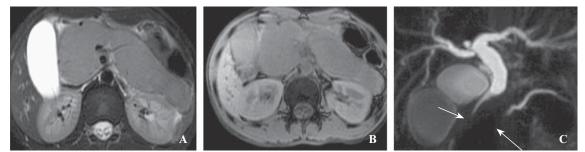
Plain MRI with abdominal axial T_2 (A) and T_1 (B) weighted images showing diffuse enlargement of the pancreas and homogeneous long T1 and long T_2 weighted signal intensities; C: Magnetic resonance cholangiopancreatography demonstrating intra- and extra-hepatic biliary dilatation to the level of the enlarged pancreatic head (white arrow) and a distended gallbladder.
